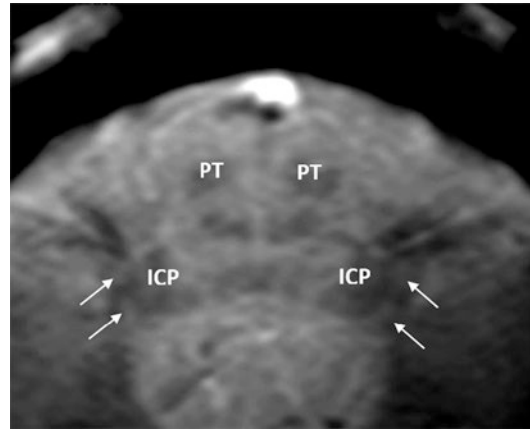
MRI Multi-Echo Fast Field Echo (mFFE) sequences at the level of the cochlear nuclei in the brainstem. Arrows indicate the normal position of the ventral and dorsal cochlear nuclei in the brainstem. The nuclei are the gray oval structures projecting on the black background of myelinated fibers of the inferior cerebellar peduncles (ICP). *PT* pyramidal tracts
